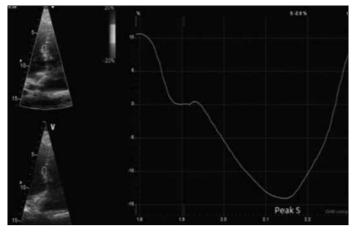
Mid septal segmental longitudinal strain analysis with transthoracic echocardiography
